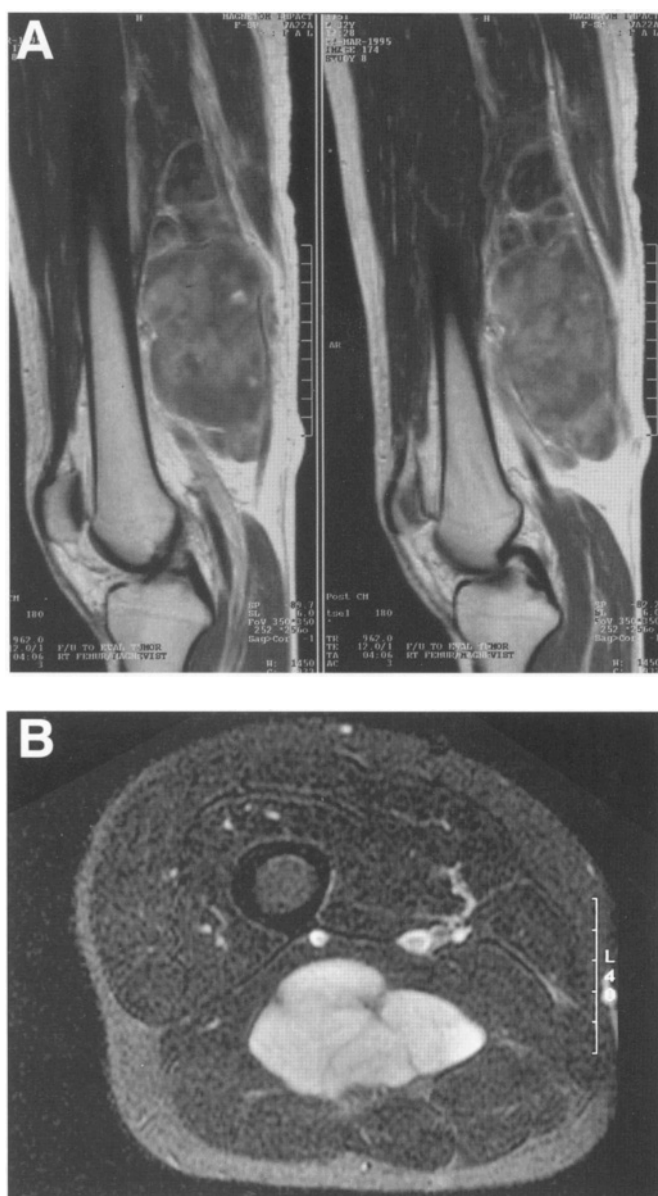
MRI scans for evaluation of posterior thigh compartment. (A) Sagittal T1 weighted image of a moderately sized posterior thigh sarcoma. Tumors of the posterior thigh often displace but rarely involve the adjacent sciatic nerve. The sciatic nerve can rarely be visualized well on an MRI scan. It is important to note that this tumor does not extend into the popliteal space as it approaches it. Angiography is utilized if tumor extends into the popliteal space. (B) Axial T2 weighted MRI scan of the same tumor that shows it arises between the medial and lateral hamstring muscles, not within the muscle itself. This is termed an extramuscular versus extracompartmental origin. The sciatic nerve cannot be well visualized and it is our policy to explore these lesions with the aim of resection and preservation of the nerve. Only if the nerve is encased by tumor is an amputation recommended. However, sciatic nerve resections with good postoperative extremity function have recently been reported.
